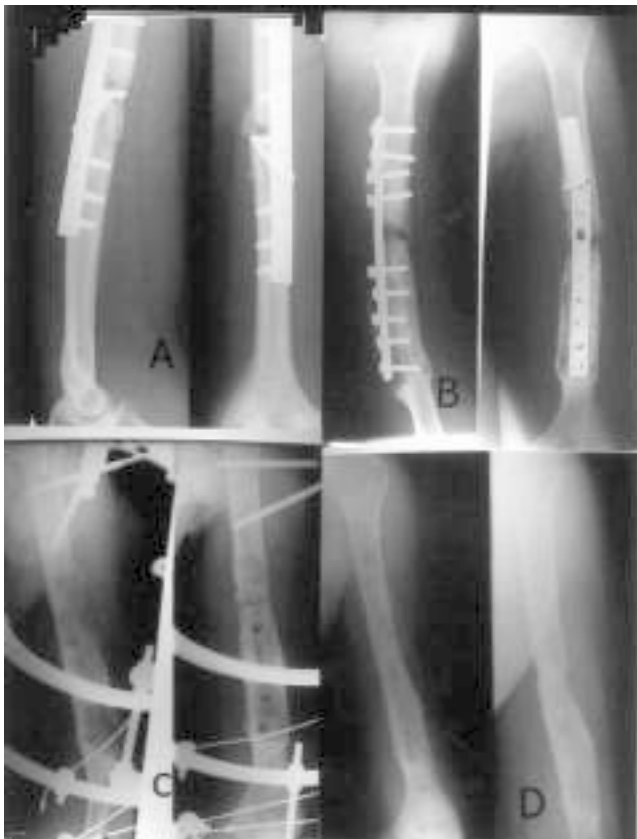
Combined photograph of a patient (JSS) showing radiographic appearance of a humeral nonunion following DCP fixation (A), refixation by DCP and bone grafting and implant failure (B), with Ilizarov fixator (C) and healed nonunion and fixator removed (D).
